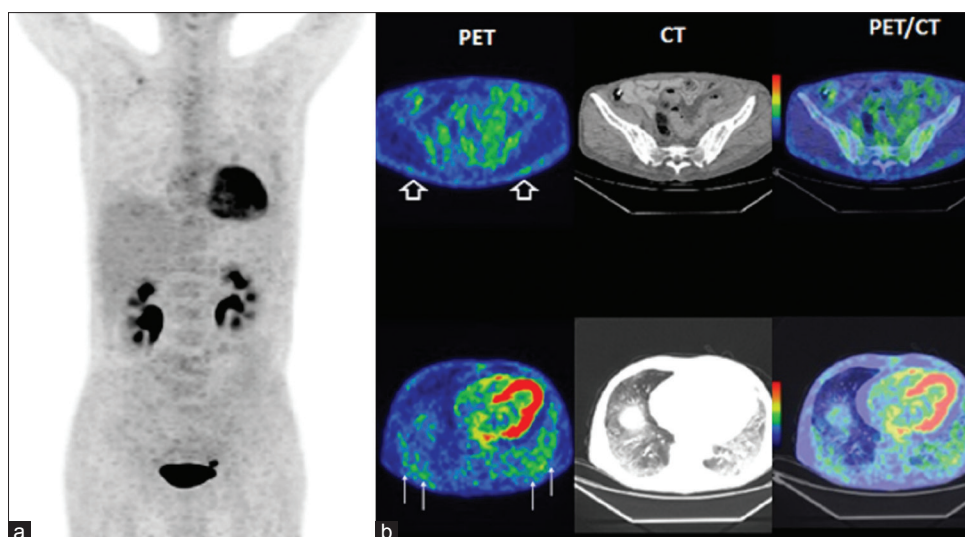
(a) Maximum intensity projection reconstruction of CT attenuation-corrected PET image data shows diffuse increased skin FDG uptake. (b) Mild FDG uptake in the inflammatory lung lesions and increased FDG uptake in the cutaneous and subcutaneous tissue higher than the neighbouring skeletal muscles are seen.
